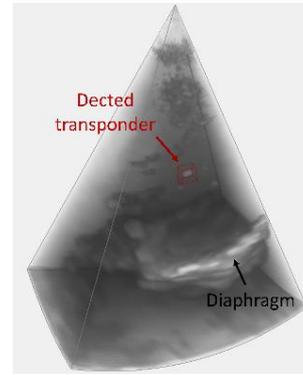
EM transponder in an ultrasound volume, detected using template matching. The diaphragm is clearly visible.
